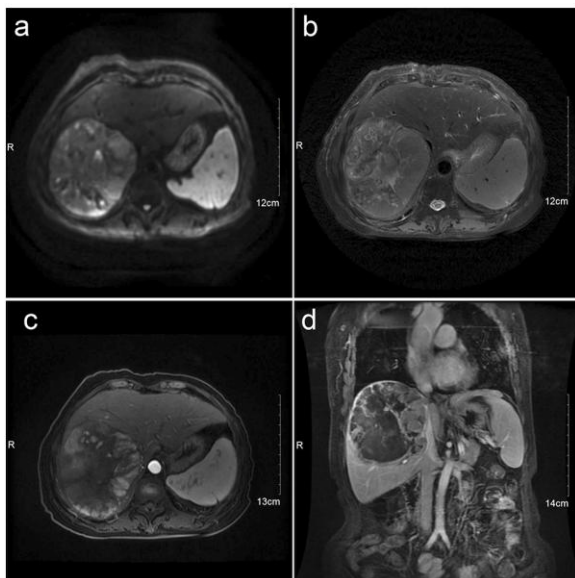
Patient A receiving cTACE treatment. The outcome of the first session of treatment. Forty days after treatment, tumor necrosis was examined by liver contrast-enhanced MRI. (a) DWI. (b) T2WI. (c) Axial, TIWI with contrast-enhanced MRI, arterial phase. (d) Coronal, TIWI with contrast-enhanced MRI, arterial phase.
